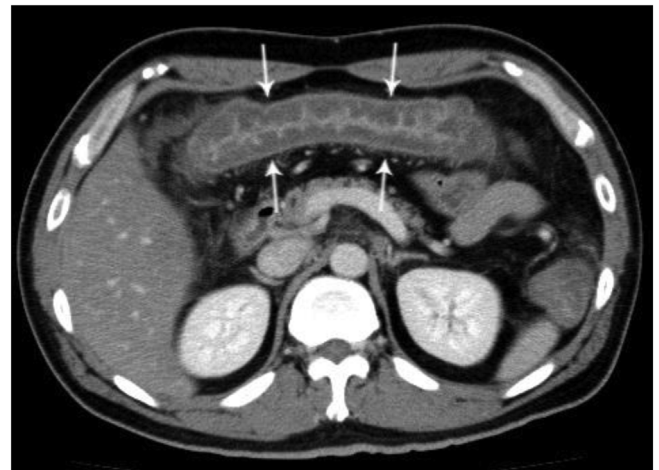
Computed tomography showing wall thickening of colon.
